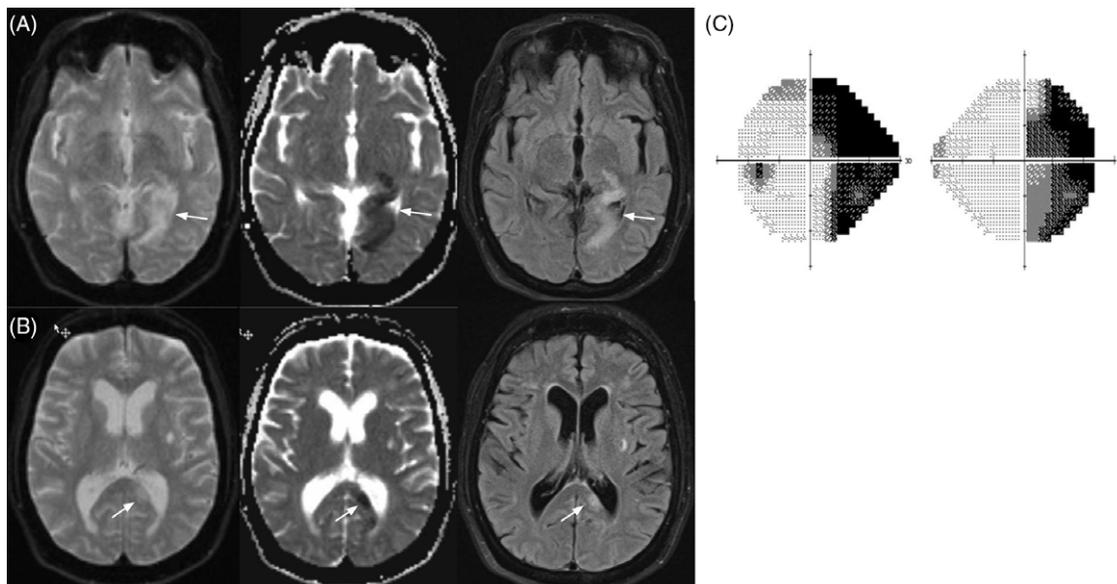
Axial MR images showing diffusion restriction (left) and associated decreased diffusion coefficient (ADC, center) involving the left thalamus, occipital-parietal lobe (A) and splenium of corpus callosum (B) that is hyperintense on T2/FLAIR (right). (C) Humphrey 24-2 visual field testing showed a near complete right homonymous hemianopia.
